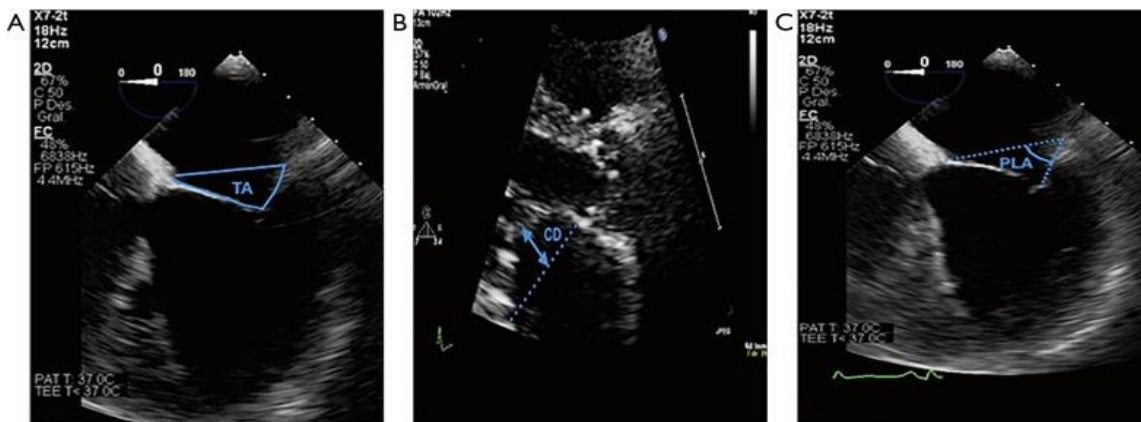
Echocardiographic evaluation of mitral valve deformation. (A) Tenting area (TA); (B) coaptation distance (CD); (C) posterior leaflet angle (13).
